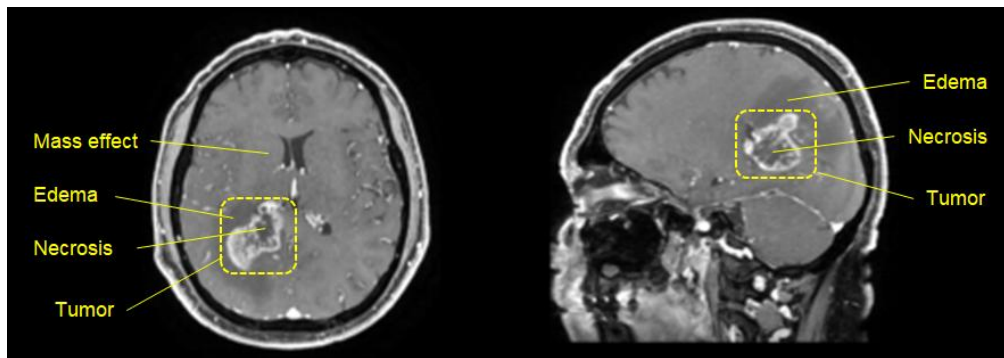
Primary glioblastoma multiforme. Axial T1 C+ fat saturated MRI (*left*) and Sagittal T1 C+ fat saturated (*right*) MRI images showing a mass abutting the right ventricular trigone and presenting peripheral enhancement and central necrosis. Case courtesy of A.Prof Frank Gaillard, Radiopaedia.org, rID: 37092.
